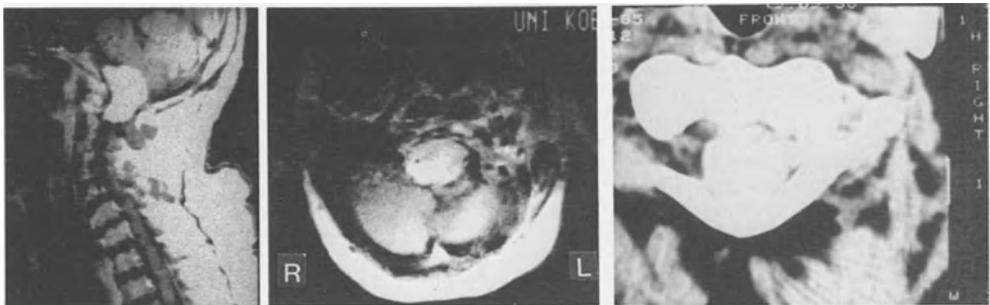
MRI (left, middle panel); CT (right panel): Huge meningioma of the foramen magnum. A small space not occupied by the tumor is still present only on the left side
